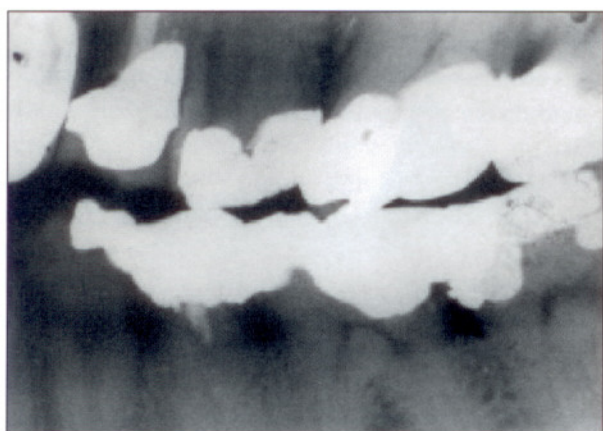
Most recent antemortem dental radiograph
